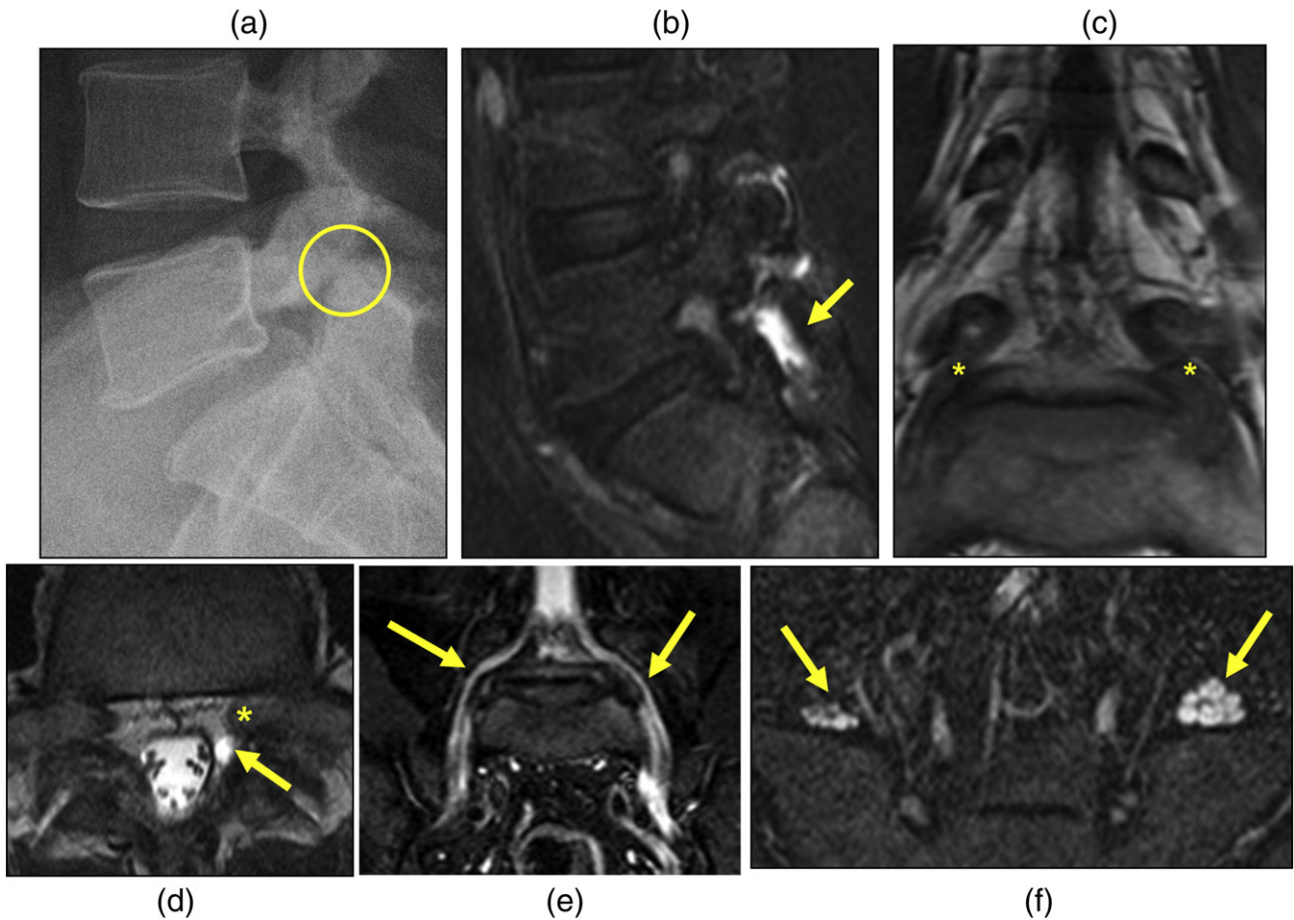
A 38-year-old man with bilateral L5 radiculopathy due to isthmic spondylolisthesis. (a) Lateral radiograph demonstrates L5 pars defects (circle). (b) Sagittal T2 fat-suppressed image shows L5-S1 facet effusion with joint diastasis. (c) Coronal T1 image shows bilateral foraminal narrowing with L5 root compression, left–right (asterisks). (d) Axial T2 image demonstrates a left L5-S1 facet synovial cyst (arrow) that contacts the left L5 dorsal root ganglion (asterisk). (e, f) Coronal and axial IDEAL T2 images from subsequent lumbar neurogram show enlarged and edematous bilateral L5 roots, left > right (arrows) due to resultant mechanical compression.
